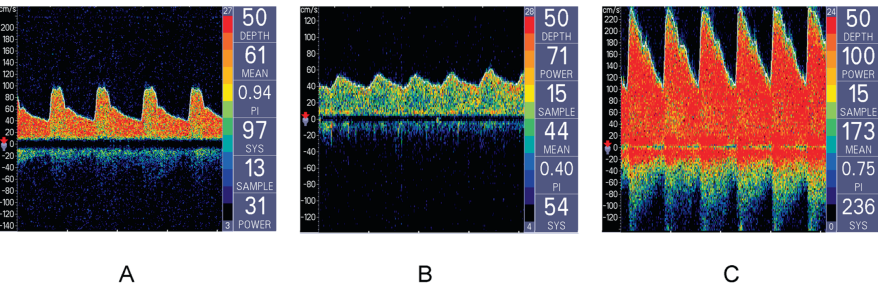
Duplex Doppler ultrasonography of the carotid bifurcation in three different patients. (A) Normal blood flow through the common carotid artery (CCA), internal carotid artery (ICA), and external
